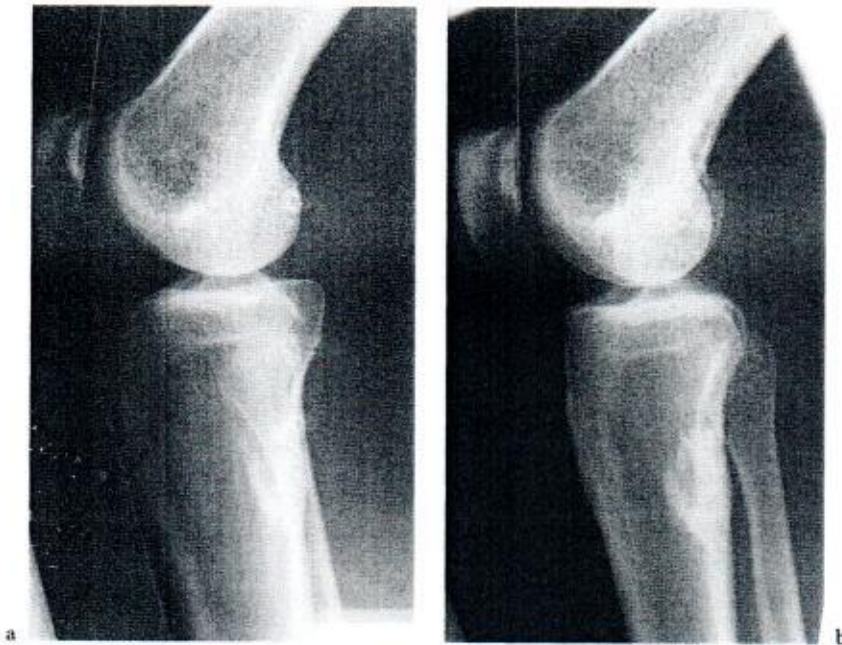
a Standing, lateral radiographic view of a knee controlled for tibial cortical sclerosis. The distal portion of the tibia is not in contact with the plate of the device (see Fig. 13.12) and the tibial plateau is not horizontal. Knee flexion is too high for the anteroposterior view. b A previous lateral view obtained in the supine position. Femoral rotation is almost identical in a and b, but there is a large difference in tibial rotation, indicated by the position of the fibula. Also there is a large difference in the position of the patella between standing (a) and supine (b), as regards both the vertical height and the articular surface orientation (gray line) relative to the tibial surface
